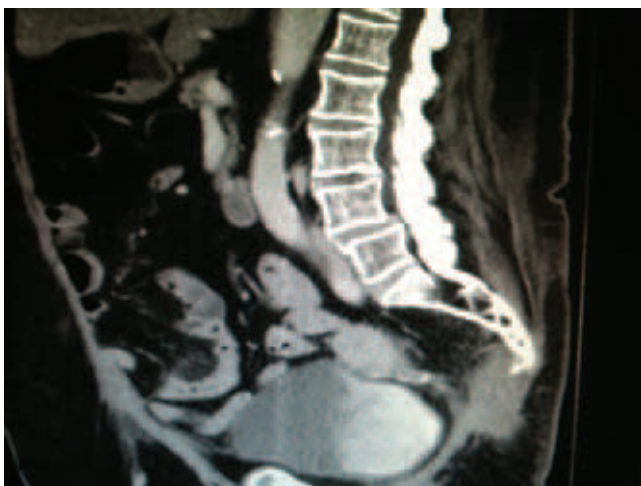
CT - sagittal view – tumor lesion aspect.
